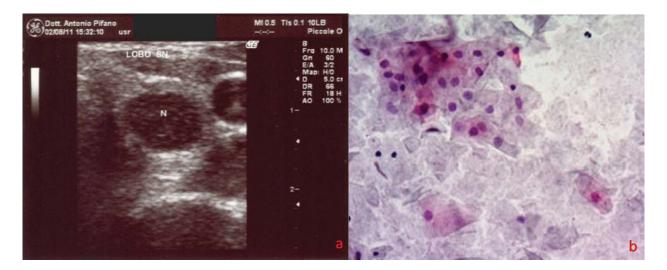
(a) Ultrasound examination: a  $1.2 \times 1,0$  cm hypoechoic nodule in left thyroid lobe; (b) Cytological examination: nucleated and anucleated squamous cells in a background with debris, without any type of inflammation (UF-Papanicolaou,  $\times 20$  original magnification). [Color figure can be viewed in the online issue, which is available at wileyonlinelibrary.com.]
